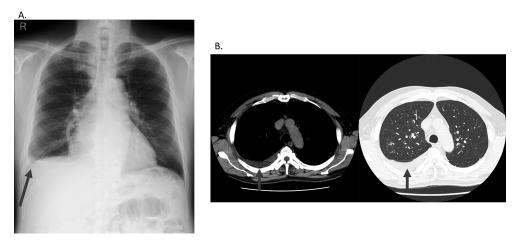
A Plain radiography of the chest on admission to the hospital reveals blunting of the right costophrenic angle. B Computed tomography reveals right-sided pleural effusion and ground-glass infiltration of the right lung.
